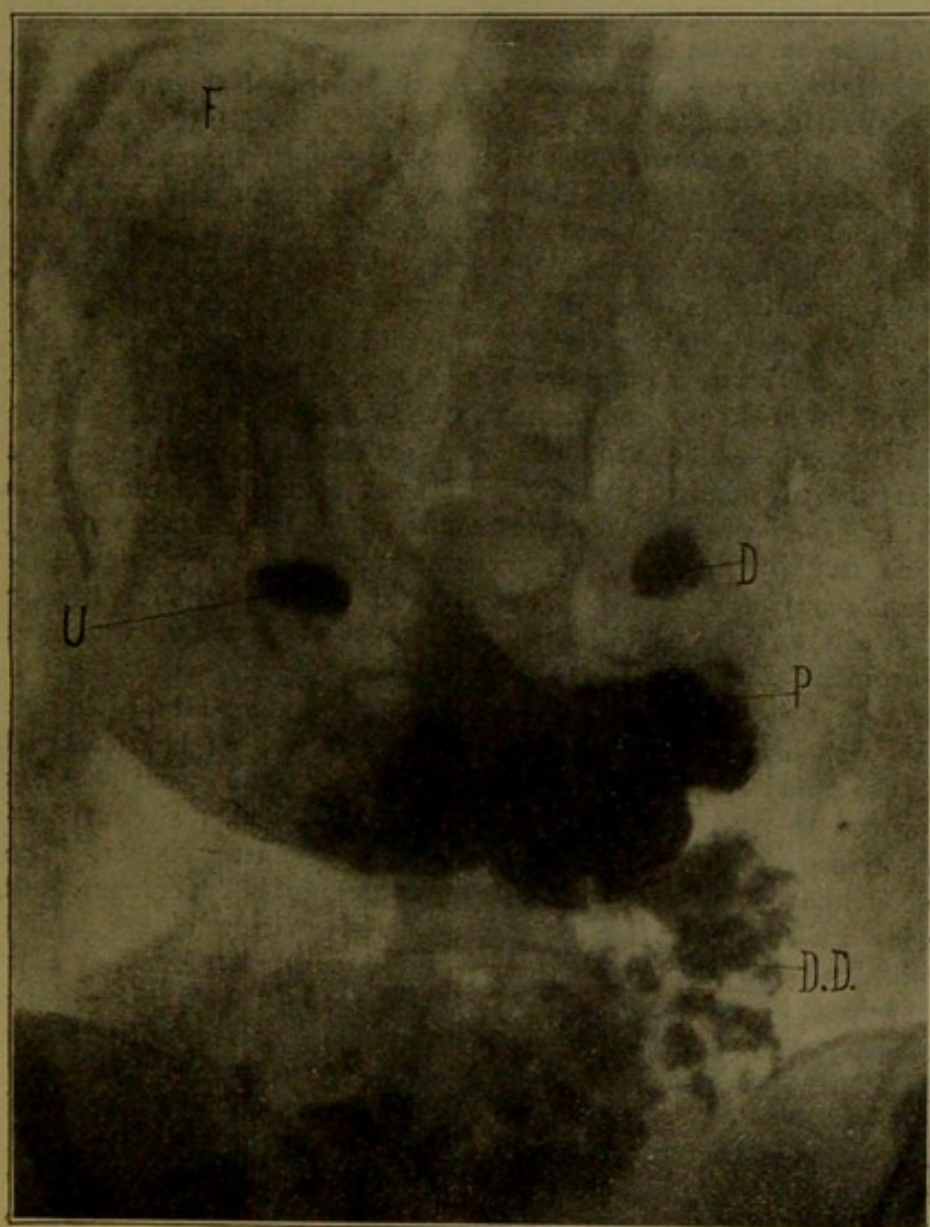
X-ray plate of the patient, showing the ulcer, the large and prolapsed stomach and the hypermotility. U, ulcer; D, first part of the duodenum; P, pylorus; DD, lower portion of the duodenum; and F, fundus with the stomach rugæ below it.
